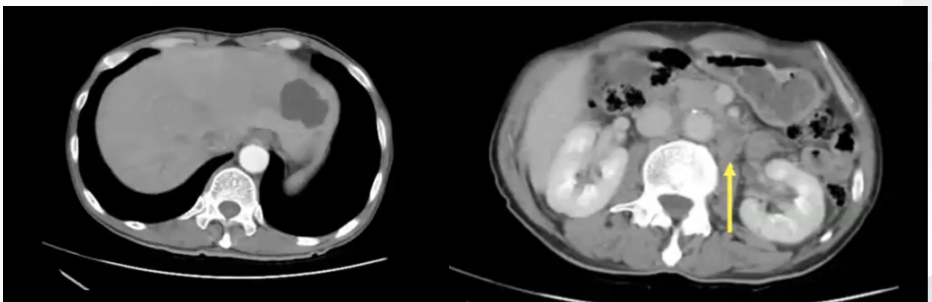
Abdominal CT images before treatment (in May 2021)
